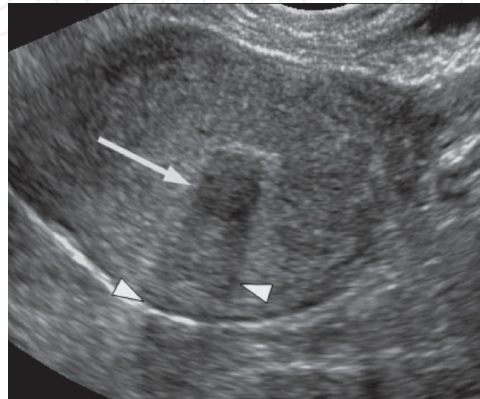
Ultrasonographic depiction of uterine fibroid.(Arrow). Wilde Sue and Scott-Barrett Sarah. Radiological appearances of uterine fibroids. Indian J Radiol Imaging. Aug 2009; 19(3): 222–231.
